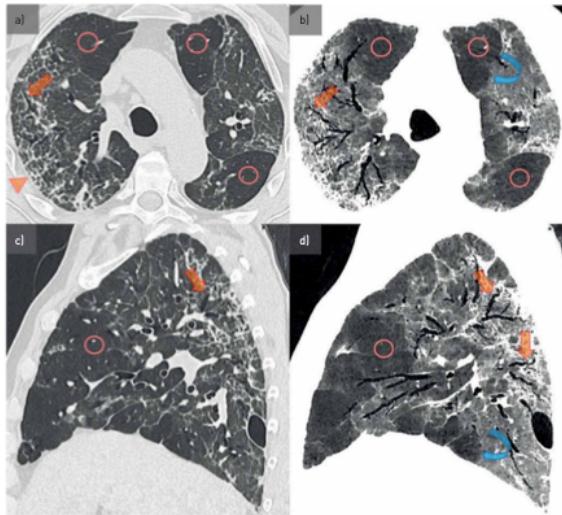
Characteristic radiological changes of a patient with severe sequelae 3 months after coronavirus disease 2019 (COVID-19) pneumonia. Extensive involvement of both lungs is present in a patient 3 months after severe COVID-19 pneumonia. Diffuse mosaic attenuation pattern in all lung lobes seen on a) axial 1-mm-thick computed tomography (CT) scan and b) 10-mm-thick minimum intensity projection (mIP) slices, c) 1-mm-thick CT and d) 10-mm-thick mIP sagittal reformats in lung windowing. This combines classical features of lung fibrosis with architectural distortion, reticulations, honeycombing (arrowhead in a) and traction bronchiectasis (straight arrows in a-d), as well as sharply demarcated areas of low attenuation in both lungs (circles in a-d). Clusters of contiguous hypoattenuating lobules and traction bronchiectasis are better visualised on mIP images with narrow window settings (b and d). Note the bulging of the interlobular septae (b and d, curved arrows) as well as the subpleural pneumatocele in c and d.
